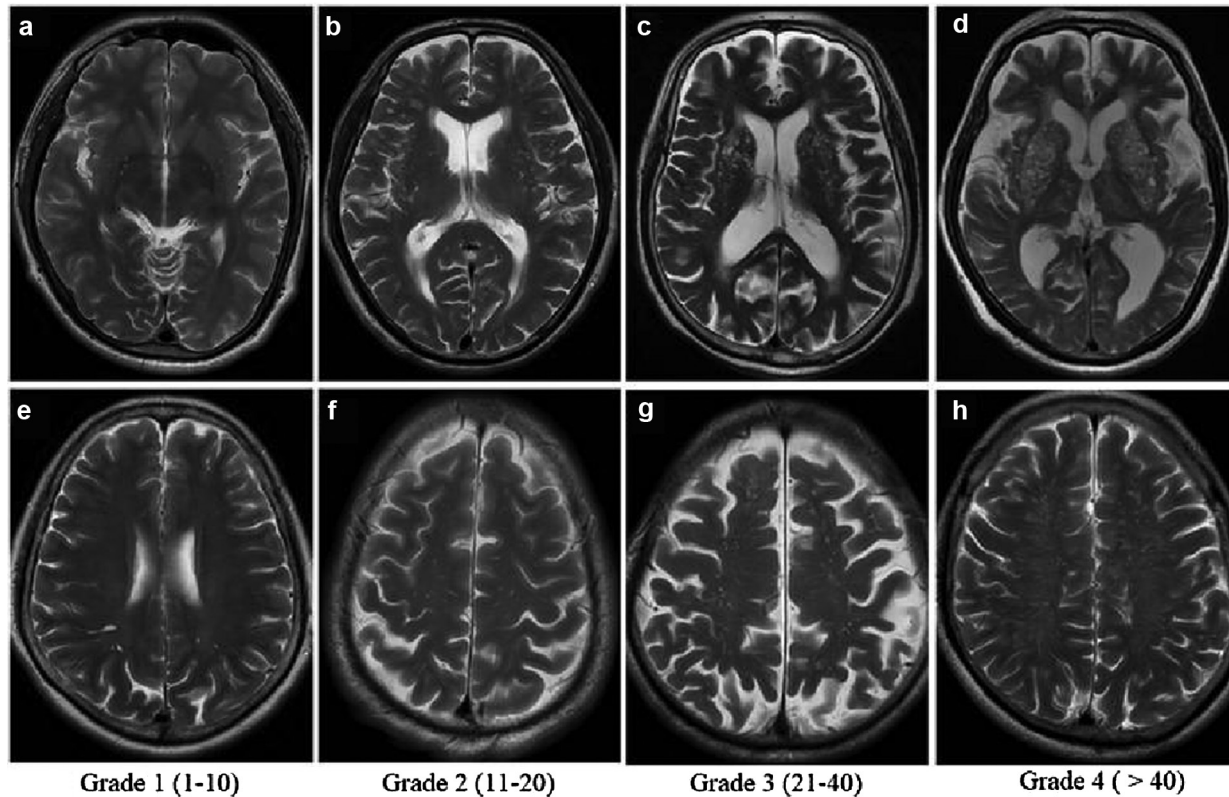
Visual rating scores for ePVS on T2-weighted MRI.
